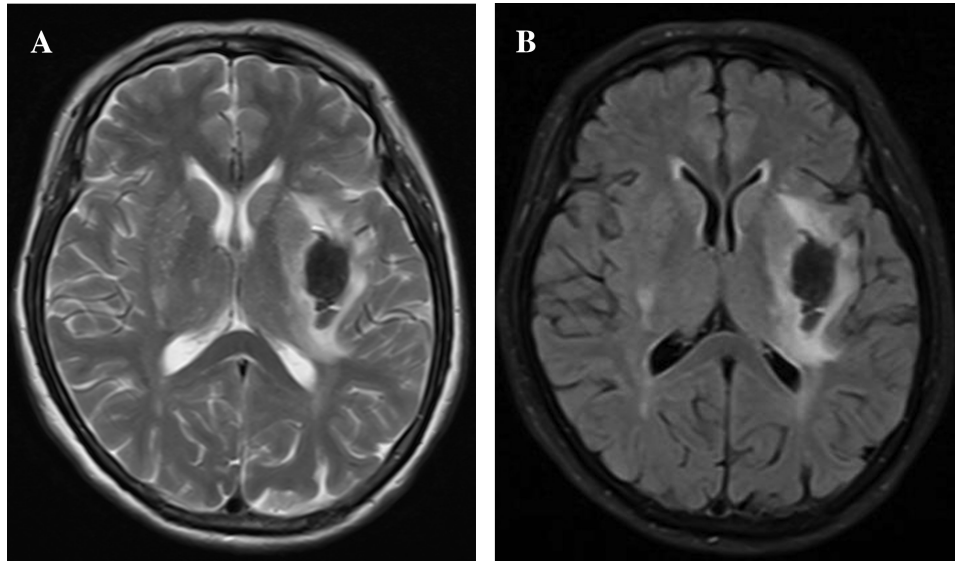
T2 MRI (A) and Flair MRI (B) showing brain edema around hematoma at the first day in a patient with an intracerebral hemorrhage.
